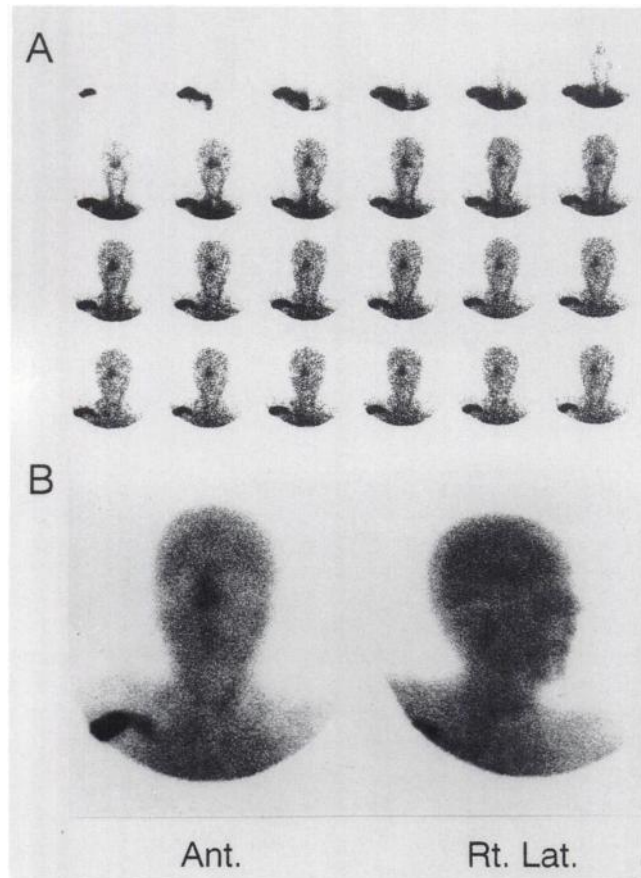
Technetium-99m-HMPAO cerebral blood flow scintigraphy showing reduced, but definite intracranial perfusion. (A) Dynamic angiography and (B) static images.
